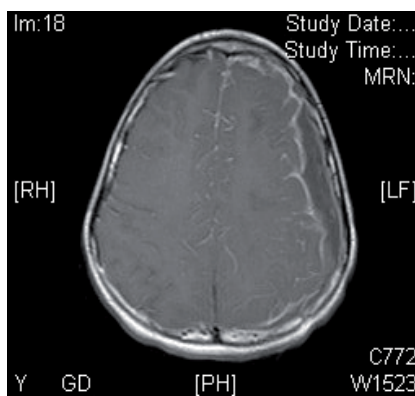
T1 contrast enhanced MRI showing large subdural empyema in left temporal-parietal region in a 9 year-old with mental status changes and paresis.
